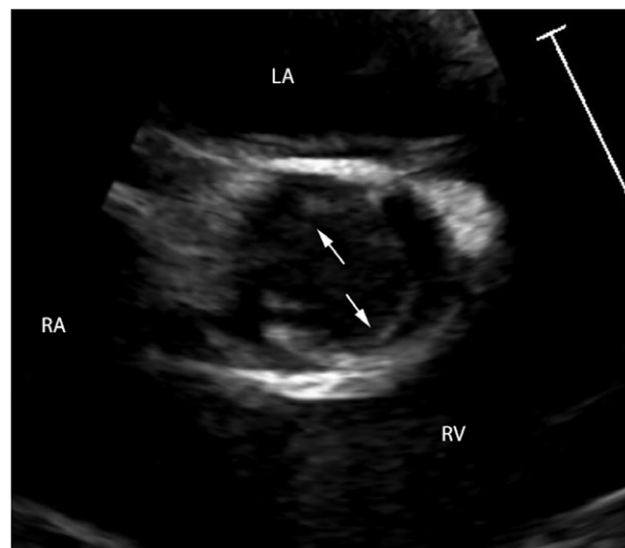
Parasternal short axis at the aortic valve view demonstrating loss of normal triangular opening shape in systole in patient with bicuspid aortic valve.
